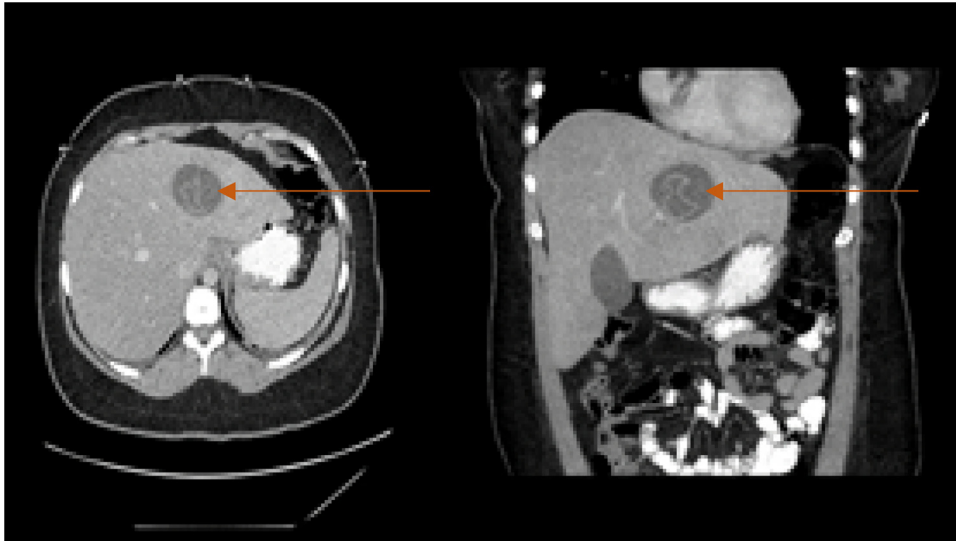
CT Abdomen showing a cyst in the left lobe of the liver with the presence of a “water-lily sign”.
